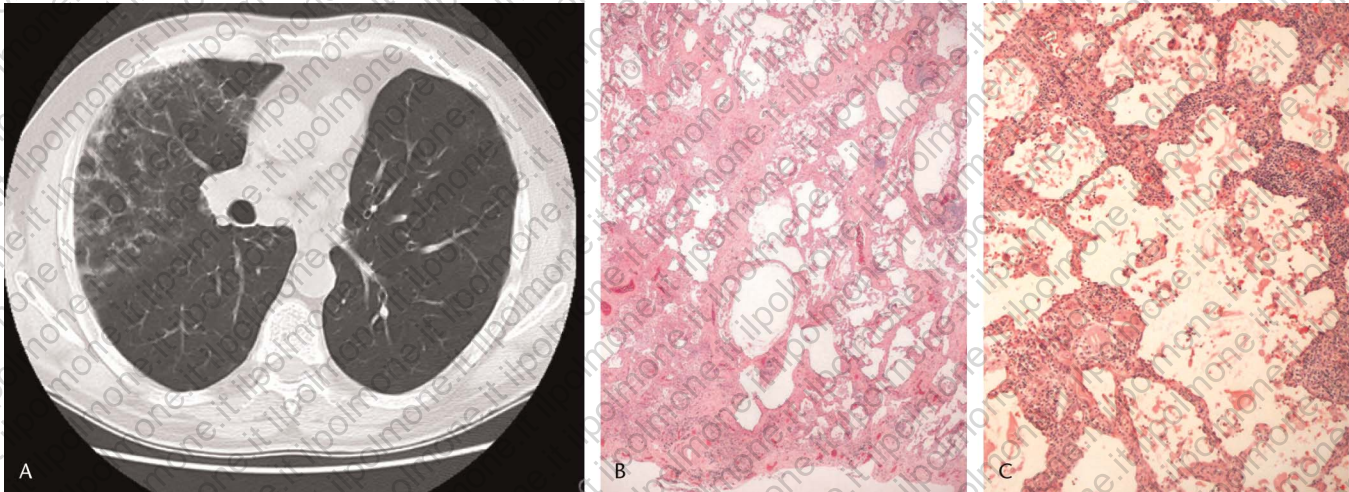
Chronic HP in a man exposed to wood dust and construction materials (case no. 7). A, CT scan image shows ground glass opacities, a few centrilobular nodular opacities, and mild peripheral reticulation in the right lung. Minimal abnormalities are evident in the left lung. The presence of reticulation suggests underlying fibrosis. B, Low power view showing marked but patchy fibrosis resembling idiopathic UIP. C, Area of subacute HP with a chronic interstitial inflammatory infiltrate and a poorly formed granuloma. *a+*
